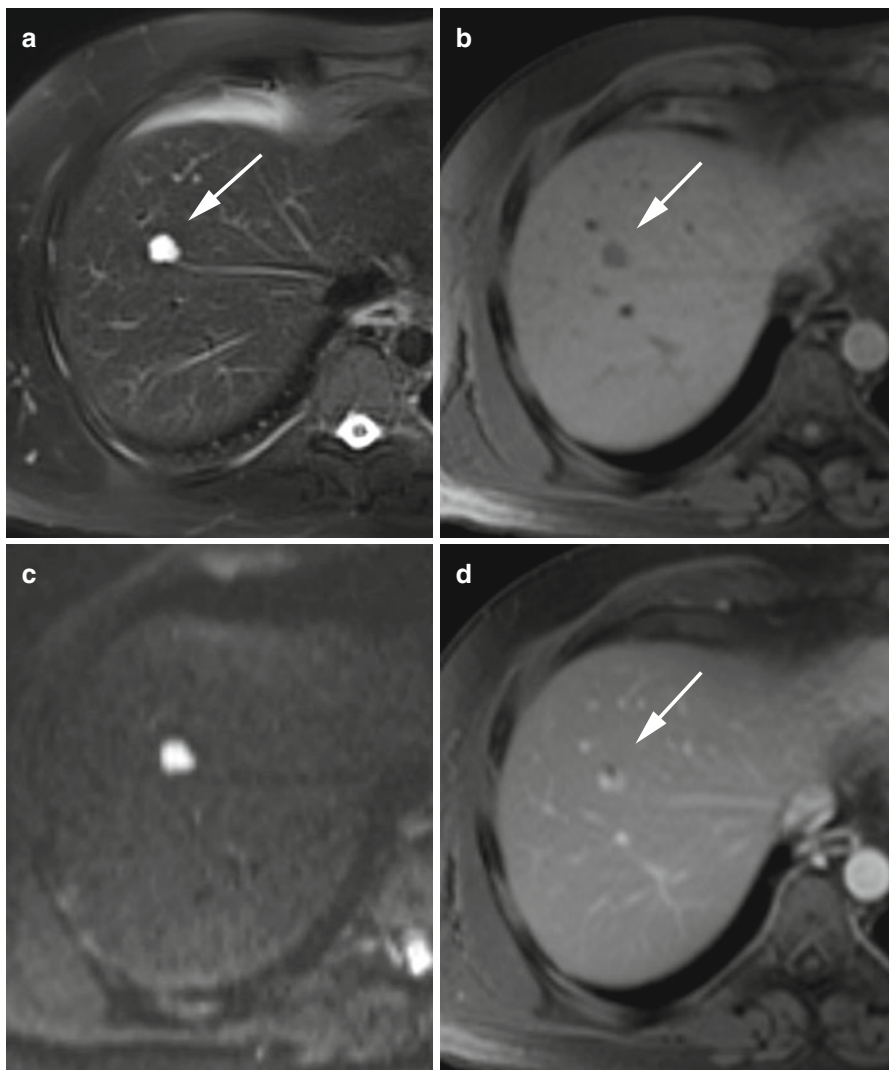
A 45-year-old male subject with an incidentally detected liver hemangioma (*arrow*). (a) Fat-saturated T2w TSE image shows a sharply demarcated mass, measuring 2.2 cm, in segment VIII. (b) On 2D T1w Flash image, the lesion has low signal intensity relative to surrounding liver. (c) On DWI, the lesion retains its high signal intensity even at high b values; the image shown was acquired with $b=800$. Liver hemangiomas have a mean ADC value of $(1.86 \pm 0.36) \times 10^{-3} \text{ mm}^2/\text{s}$ (Sun et al. 2005). (d) For lesion differentiation, an extracellular MR contrast agent was administered. On the postcontrast images, the lesion showed centripetal fill-in, consistent with hemangioma
